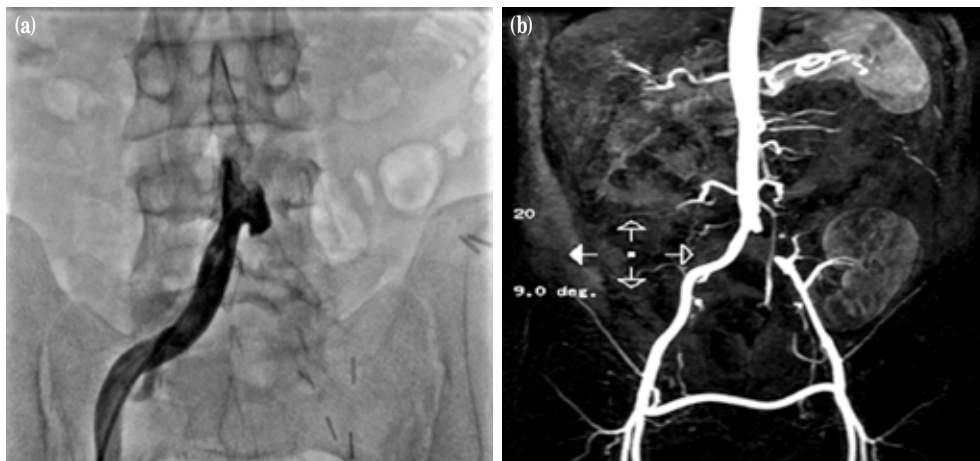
(a) Conventional angiography showing total occlusion of the left common iliac artery proximal to the anastomosis. (b) Magnetic resonance imaging angiography showing cross-over femoro-femoral bypass graft, and retrograde perfusion of renal allograft.
